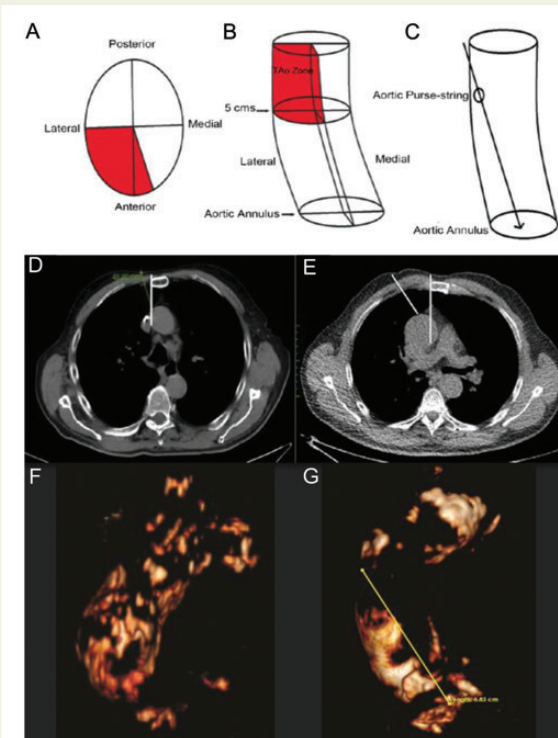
Multi-detector row computed tomography for procedural planning of transaortic transcatheter aortic valve implantation. (A and B) The transaortic zone for cannulation of the aorta along the upper lateral quadrant allowing perpendicular alignment to the aortic valve (C). Based on the spatial relationship between the sternum and the ascending aorta, the approach can be through a mini-J sternotomy (D), if the ascending aorta is in the midline or left-sided and >6 cm below the sternum (E), or through a mini-right sternotomy, if the ascending aorta is right-sided and <6 cm below the sternum. (F) Three-dimensional multi-detector row computed tomography reconstruction of the aorta demonstrating a true porcelain aorta precluding the transaortic approach. (G) Three-dimensional multi-detector row computed tomography reconstruction demonstrating a patchy porcelain aorta which permits transaortic access. The 'transaortic zone' is free of calcium. Reproduced with permission from Bapat et al.¹⁵²
